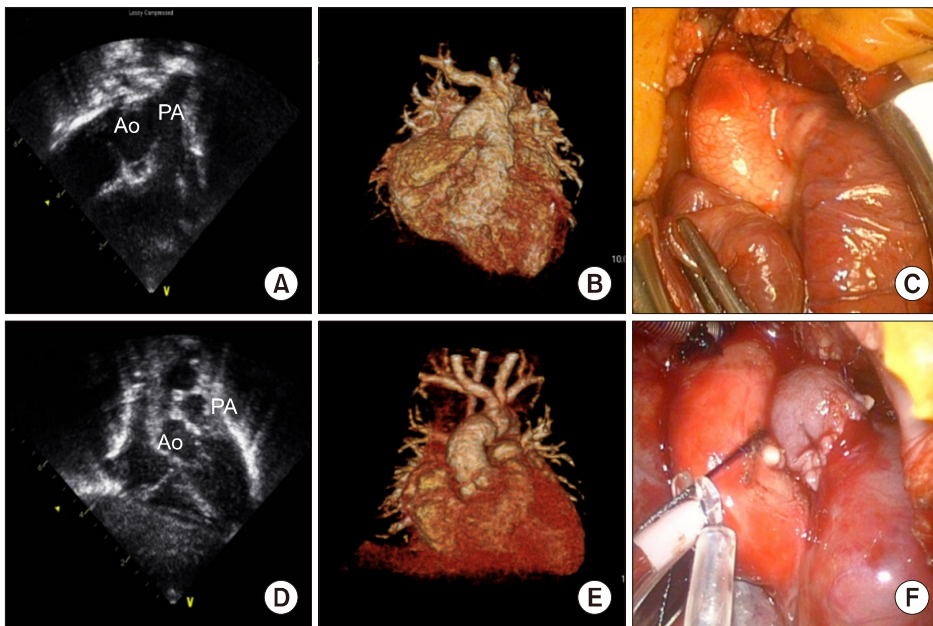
Preoperative and post-operative echocardiography (A, D), computed tomography (B, E), and operative findings (C, F) showed intermediate-type aortopulmonary window. Ao, aorta; PA, pulmonary artery.
